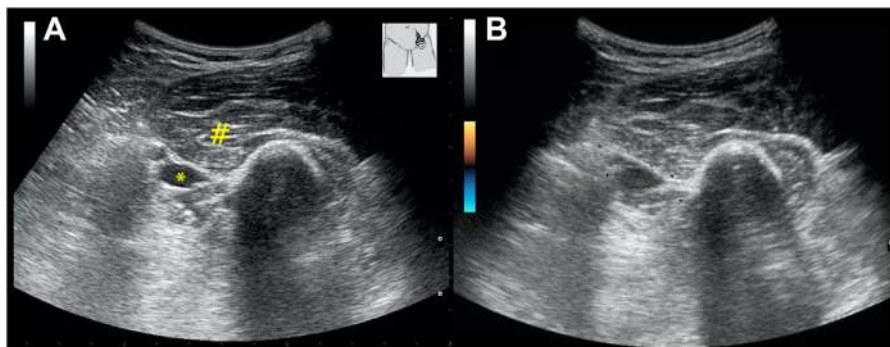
(A) Ultrasound image showing hematoma (marked as #) compressing left common femoral artery (marked as *). (B) Color Doppler image showing no color flow in the left common femoral artery.
